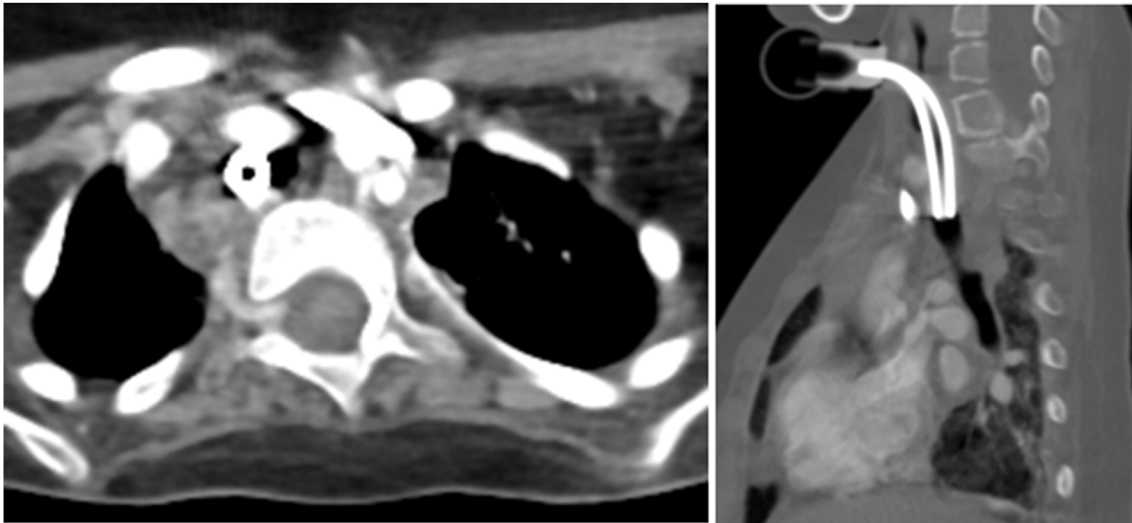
Contrast-enhanced chest CT reveals hypokyphotic spine resulting in a narrowed thoracic inlet.
